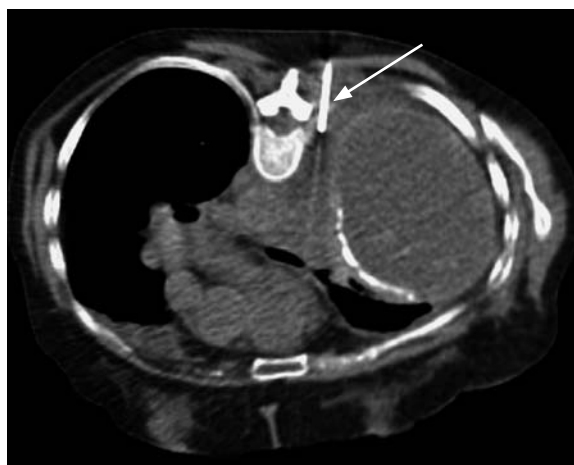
CT-guided core biopsy of left pleural thickening (arrow). Diagnosis of B-cell lymphoma was made
